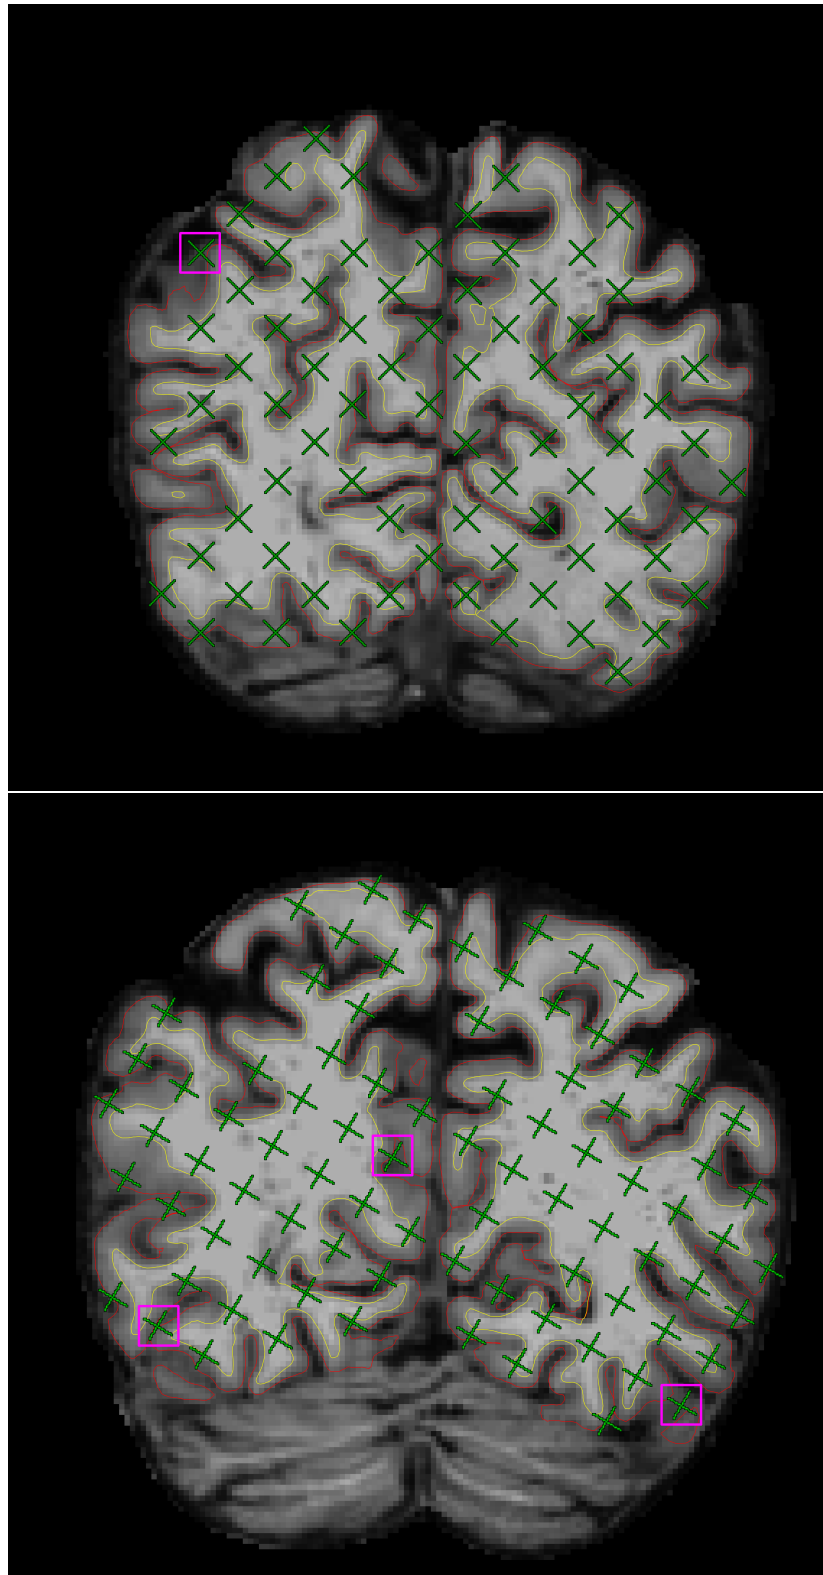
On the 4th and 5th slices of one brain MR image in the coronal view, counted test points (green) hitting the cerebrum (excluding ventricles) are overlaid onto pial profiles (red lines) segmented by FREESURFER. Rectangles (pink) mark the counted test points which fall outside the grey matter boundaries (red lines).
